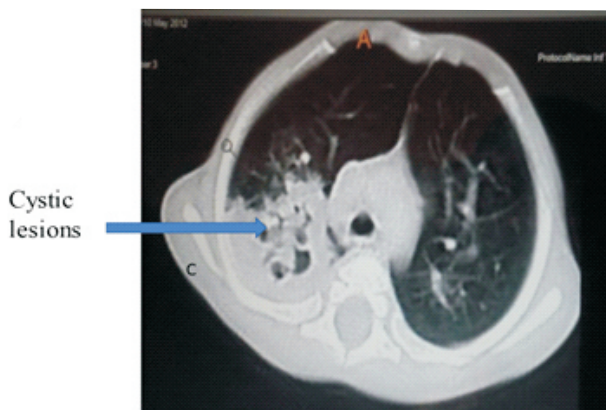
Thoracic CT scan showing a right upper and middle lobe and left upper lobe CPAM in a 7-month-old infant. The most prominent features are cystic and solid areas in the right lung
